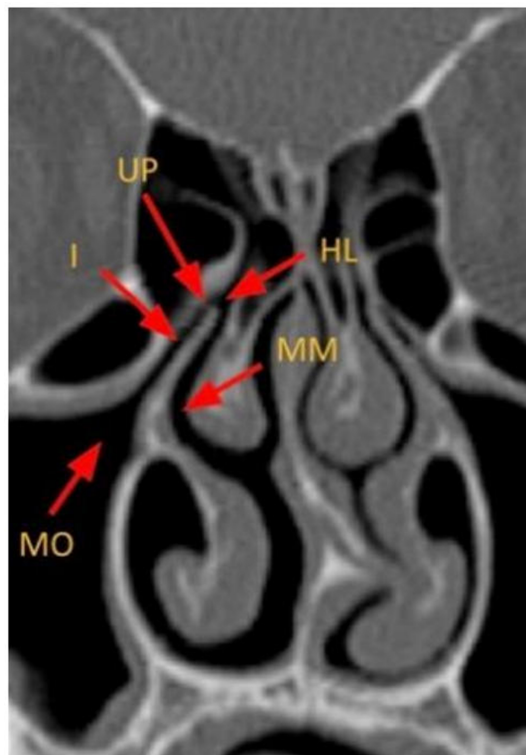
Coronal CT image depicting the key anatomy of the anterior OMU. MO: Maxillary ostium; I: infundibulum; HL: hiatus semilunaris; MM: middle meatus; UP: uncinate process; CT: computed tomography; OMU: ostiomeatal unit.
